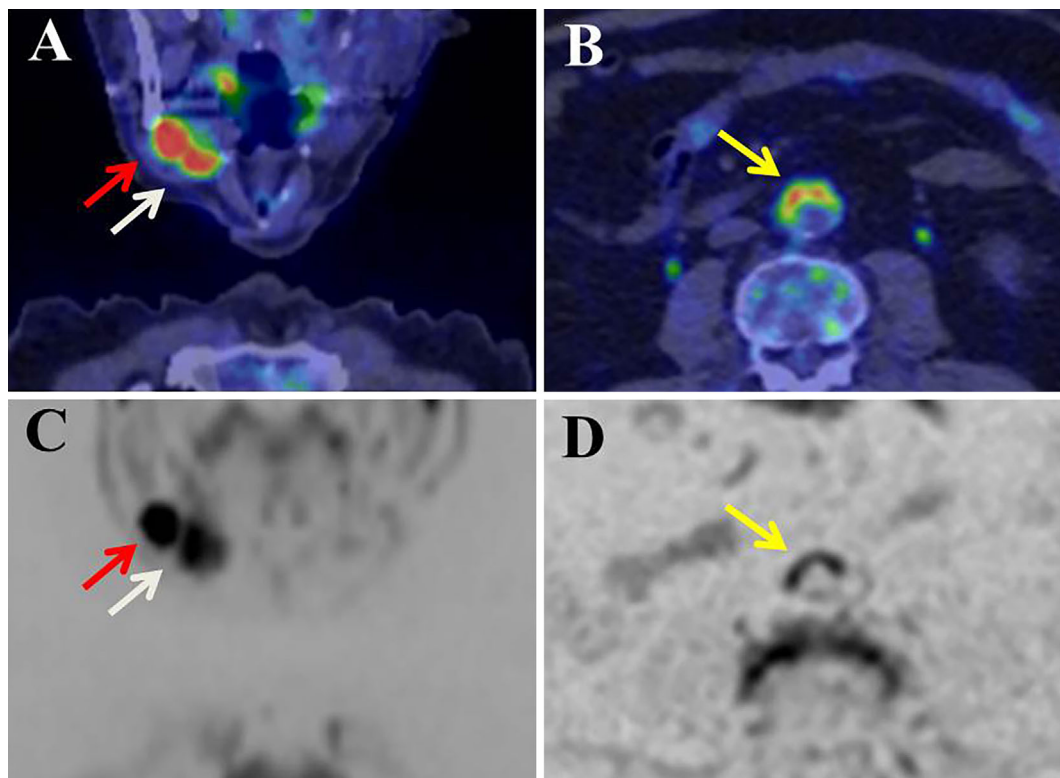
(A) Coronal image of FDG-PET/CT before the treatment. The accumulation of FDG is observed in the submandibular gland (white arrow) and lymph nodes (red arrow). (B) Axial image of FDG-PET/CT before the treatment. The accumulation of FDG is observed in the abdominal aorta (yellow arrow). (C) Coronal image of DWIBS before the treatment. High signals are also observed in the submandibular gland (white arrow) and lymph nodes (red arrow). (D) Axial image of DWIBS before the treatment. High signals are observed in the abdominal aorta as well (yellow arrow).
